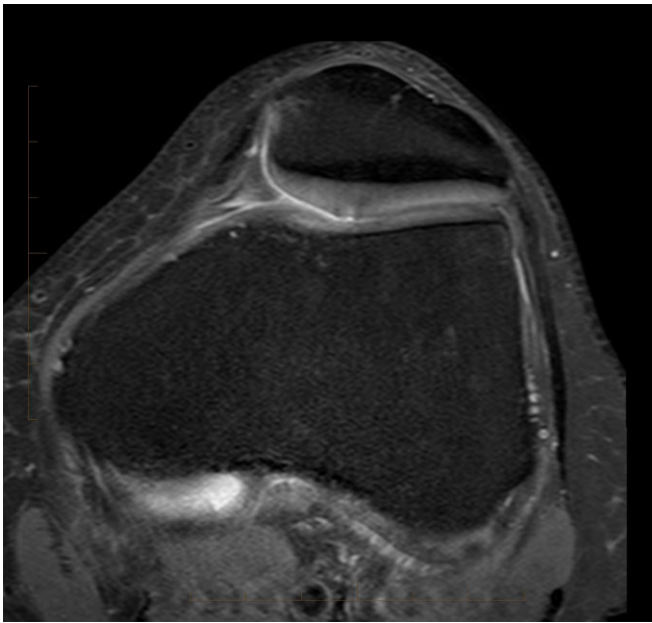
A 43-year-old male with anterior knee pain. 3T MRI Proton density fat suppressed image in transverse plain, shows Grade 2 chondromalacia patellae at the patella apex.
